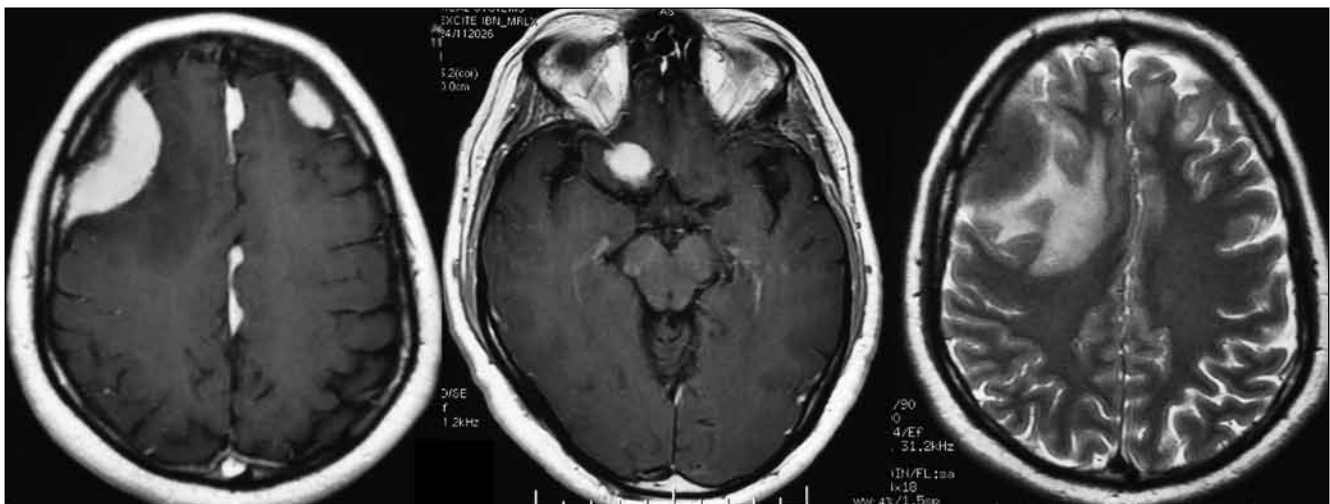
Axial T1-Weighted with contrast (left and right), T2-Weighted (middle) MRI images of case 1, showing the dural-based lesions.
